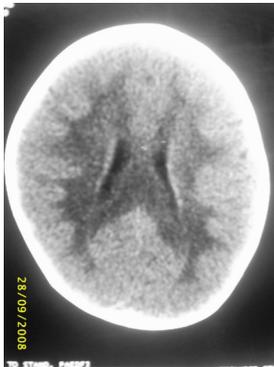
Axial CT scan of brain at the level of basal ganglia in an HIV patient (CD4 count 100 cell/ μ L -500cell/ μ L) shows cerebral edema, hypodense lesions affecting the internal capsule, caudate nucleus and occipital lobes.
